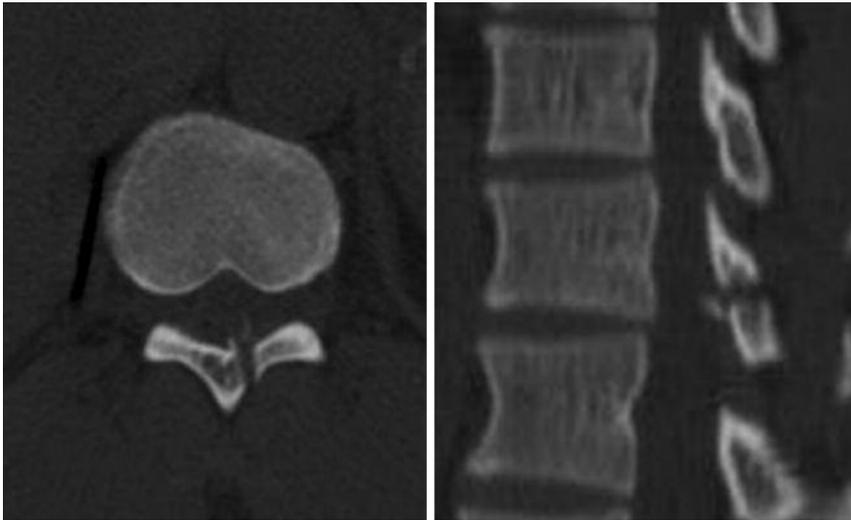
CT scan shows the bone lesion caused by the awl.
